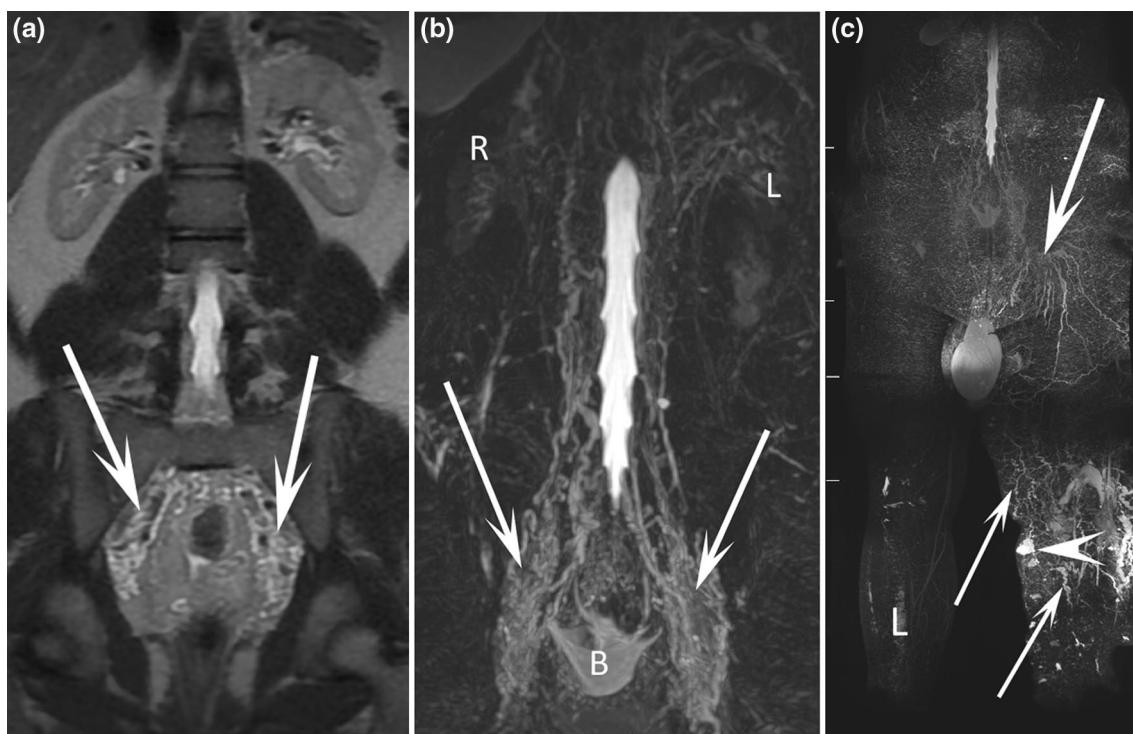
17-year-old male patient with chyluria, hydrocele, and bilateral lymphedema of the lower limbs. Coronal T2-weighted MR image (a) and coronal MR lymphography with MIP reconstruction (b) demonstrated widespread dilated lymphatic vessel development along the urinary tract from the retroperitoneum to the bladder (arrows). R right kidney, L left kidney. Coronal MR lymphography with MIP reconstruction (c) demonstrated major lymphatic dysplasia at the root of the left lower limb (arrows) and the presence of several cystic lymphatic malformations (arrowhead) of the soft tissues
